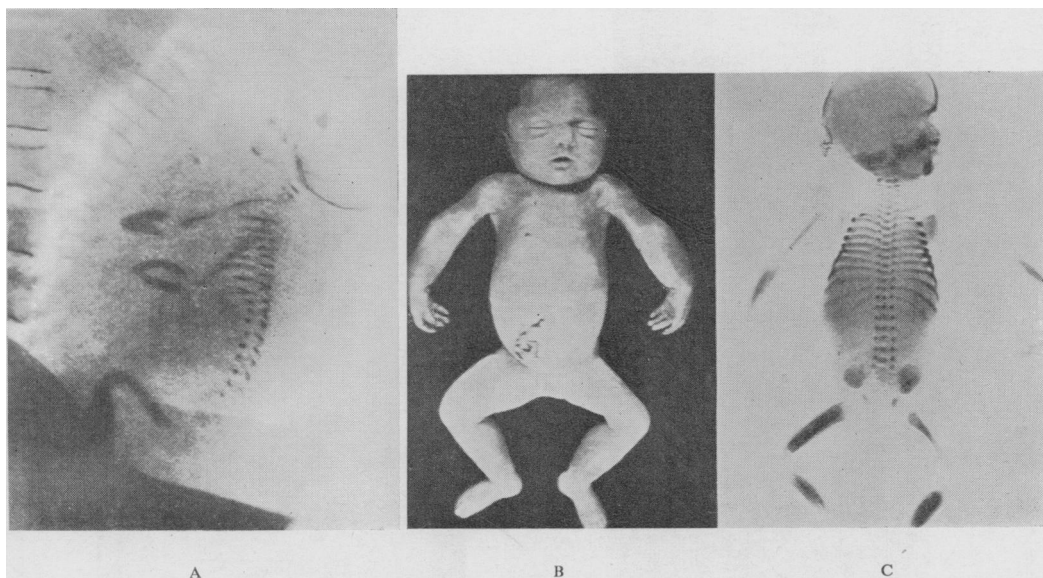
Prenatal infantile cortical hyperostosis in a fetus 31 weeks of age. A, massive hyperostoses in the bones of the extremities in a lateral projection of the fetus *in utero*. B, photograph of the dead fetus after delivery by Caesarean section. Swellings of the face and extremities are similar to those of postnatal ICH. C, roentgenogram of the fetus *ex utero* shows hyperostoses in the mandible, ribs, and tubular bones in the extremities which are similar to those found in postnatal ICH [C, Reproduced by kind permission; Bennett and Nelson, 1953].
